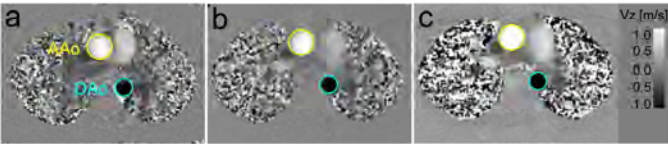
Peak Systolic phase difference images (V_z component) of the aorta obtained using 2D CINE PC-MRI with single-directional through-plane (a), interleaved (b) and sequential (c) 3-directional velocity encoding, respectively.
